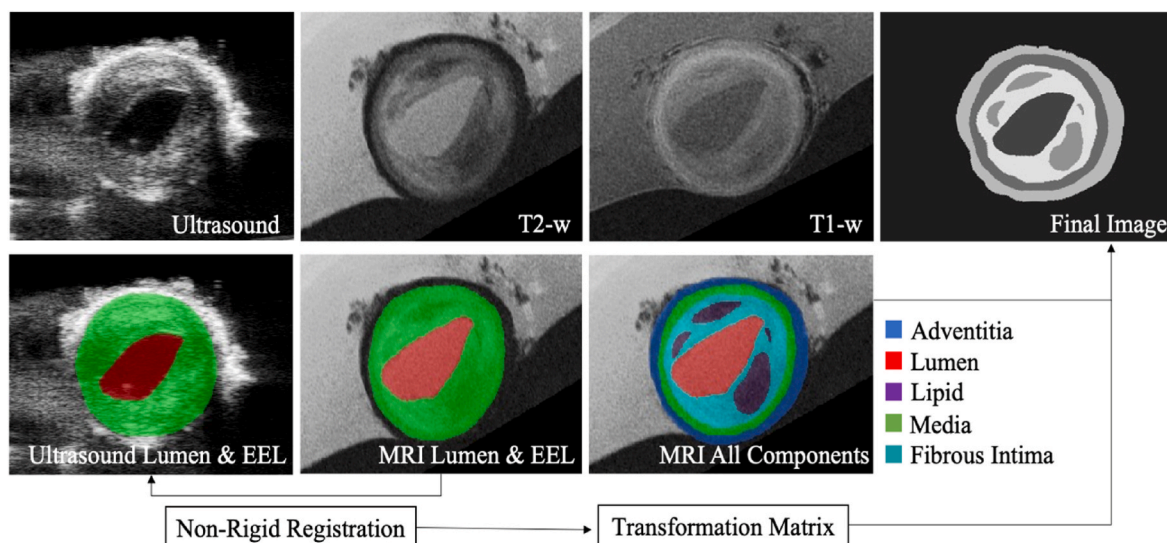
Ultrasound and co-registered T1 and T2-weighted MR images of a sample with lipid pools. The lumen (red) and external elastic lamina (EEL) (green) were segmented both on the ultrasound and MR images to obtain the transformation matrix by the non-rigid registration. Then, the transformation matrix was applied on the lumen (red), fibrous intima (turquoise), lipid (purple), media (green) and the adventitia (blue) segmented T2-weighted MR image to obtain the final registered image.
